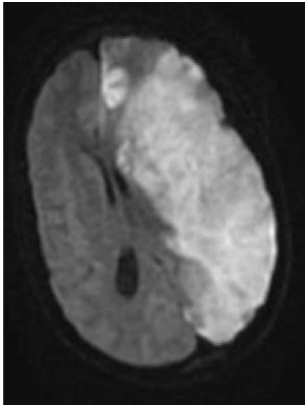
Final DWI MRI of the brain, displaying acute ischemia of the entire left cerebral hemisphere with left to right midline shift.
